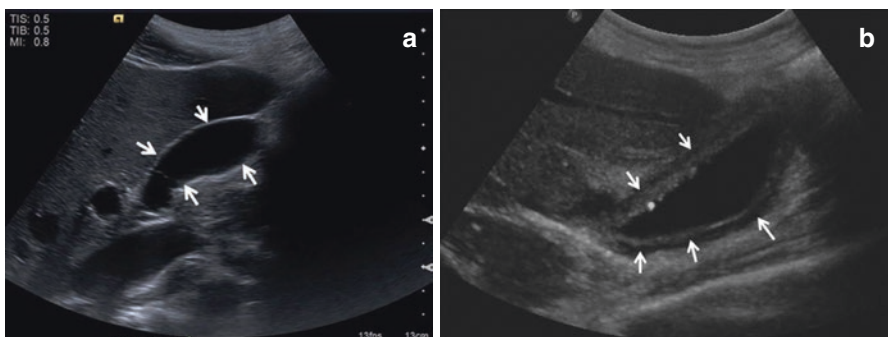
a RUQ ultrasound of a normal thin-walled gallbladder. b RUQ ultrasound showing a thickened, edematous gallbladder wall consistent with acute cholecystitis. (Used with permission. de Virgilio [8])
